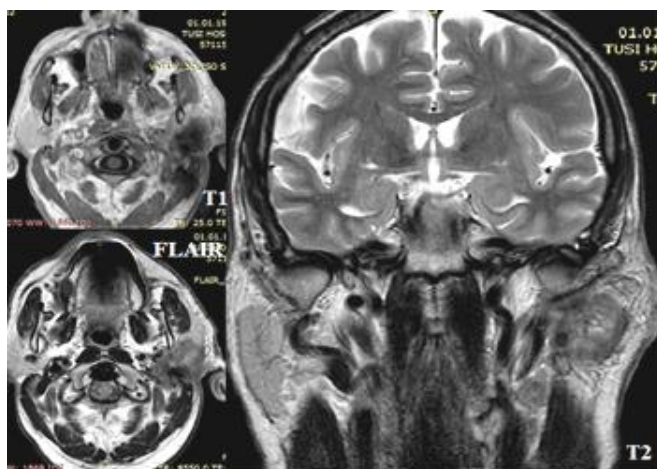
Patient M. R., male, 66 years old, a/c 0223. In the T2 weighted MRI mode, the isointensity of the tumor tissue is detected, inside the areas with T2-hyperintensive signal. On T1 weighted MRI has a hypointensive signal. There is an invasion of the surrounding fat tissue.
